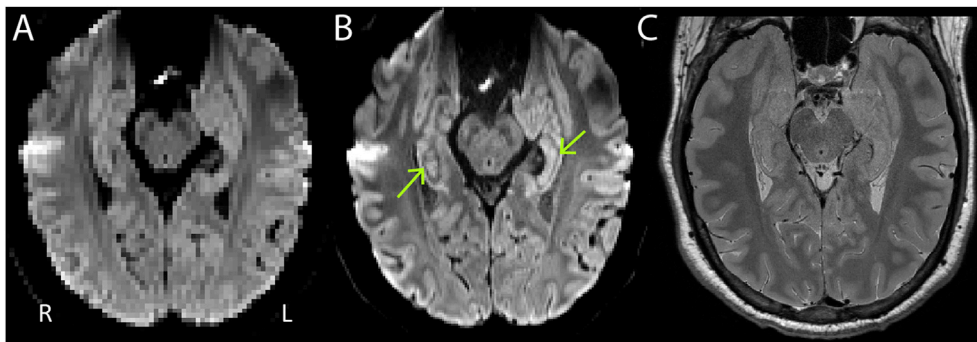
The axial mean diffusion weighted image (average of 128 $b = 500 \text{ s/mm}^2$ DWIs) of a single slice for a healthy 30 year old male is shown for (A) $2 \times 2 \times 2 = 8 \text{ mm}^3$ resolution and (B) $1 \times 1 \times 1 = 1 \text{ mm}^3$ resolution. The $1 \times 1 \times 1 \text{ mm}^3$ 6 min acquisition provides an 8-fold increase in spatial resolution, allowing visualization of hippocampal substructure (e.g. SLM, indicated with arrows) that is not appreciable in the 2 mm isotropic scan. (C) The same slice in a conventional fast spin echo $1 \times 1 \times 1 \text{ mm}^3$ T2-weighted scan (20 slices; TR = 5440 ms, TE = 52 ms) shows excellent grey-white contrast but less delineation of structure within the hippocampus relative to the DWI.
